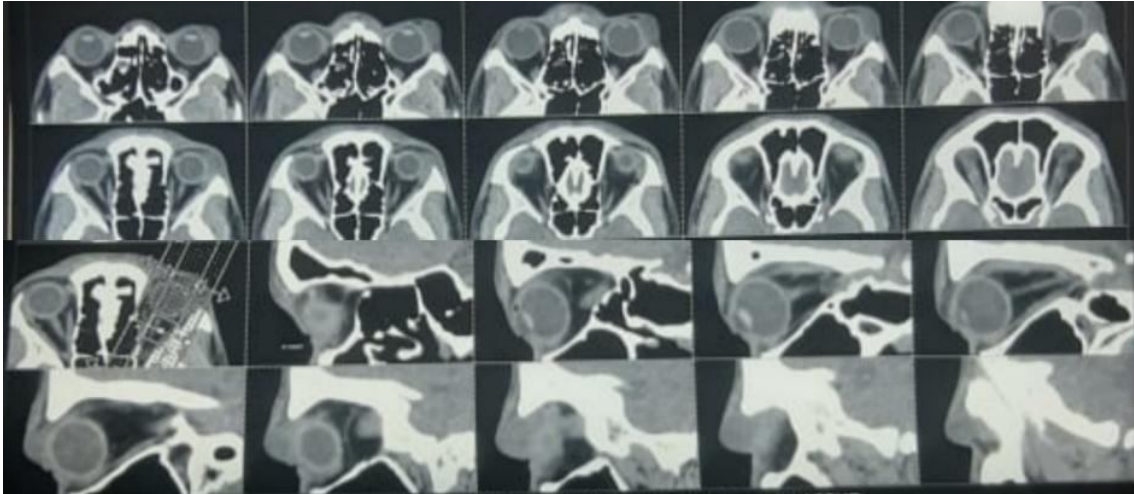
CT orbit showing hypodense cystic lesion.
